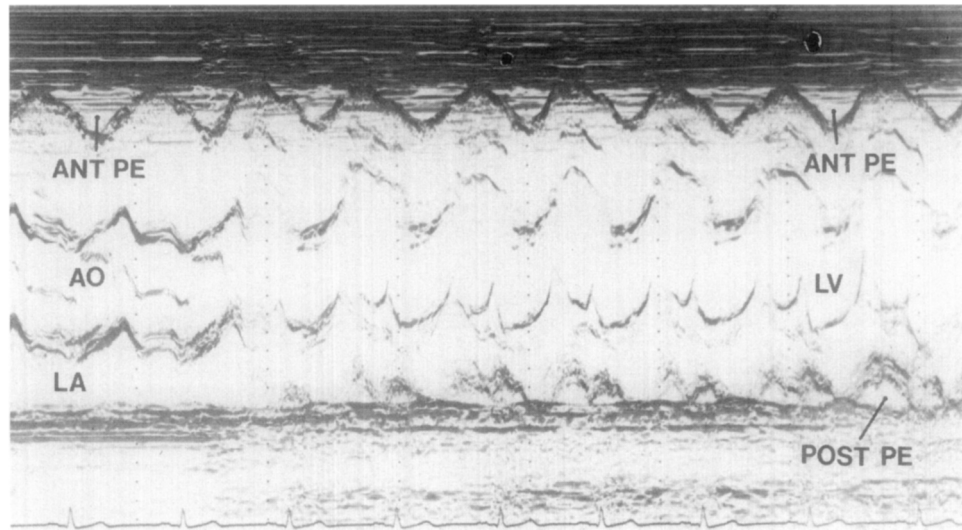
M-mode echocardiogram demonstrating anterior and posterior pericardial effusion (*PE*). The effusion is not visualized behind the left atrium (*LA*). *LV* = left ventricle; *AO* = aorta.
